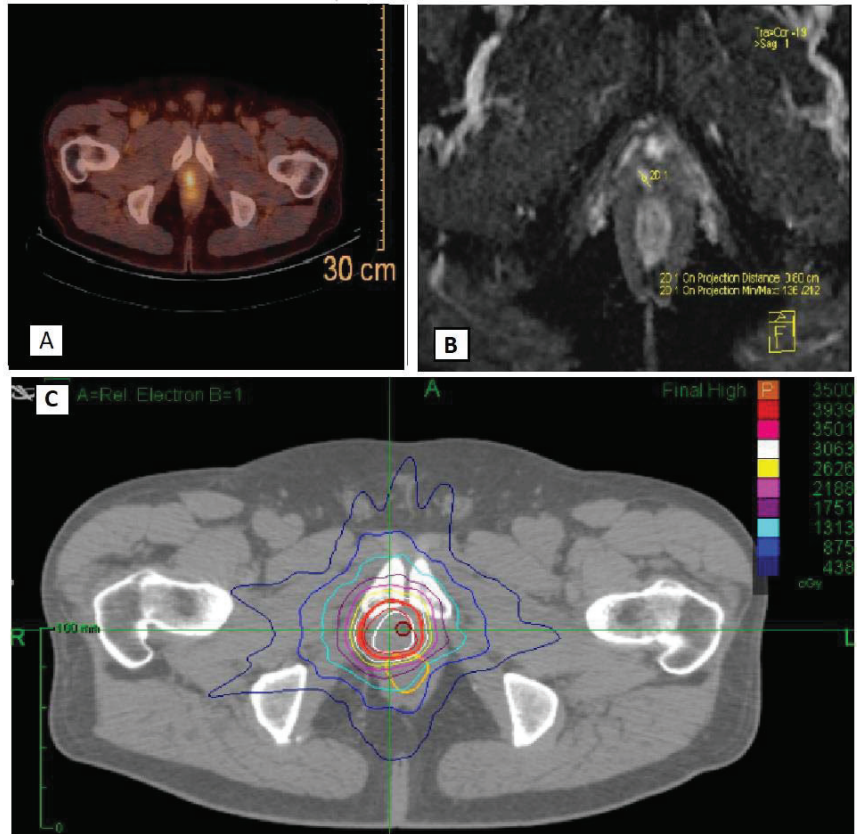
An example of radiotherapy treatment plan with PSMA imaging (A), MRI imaging (B) and Cyberknife^R treatment volumes and isodose lines (C).
